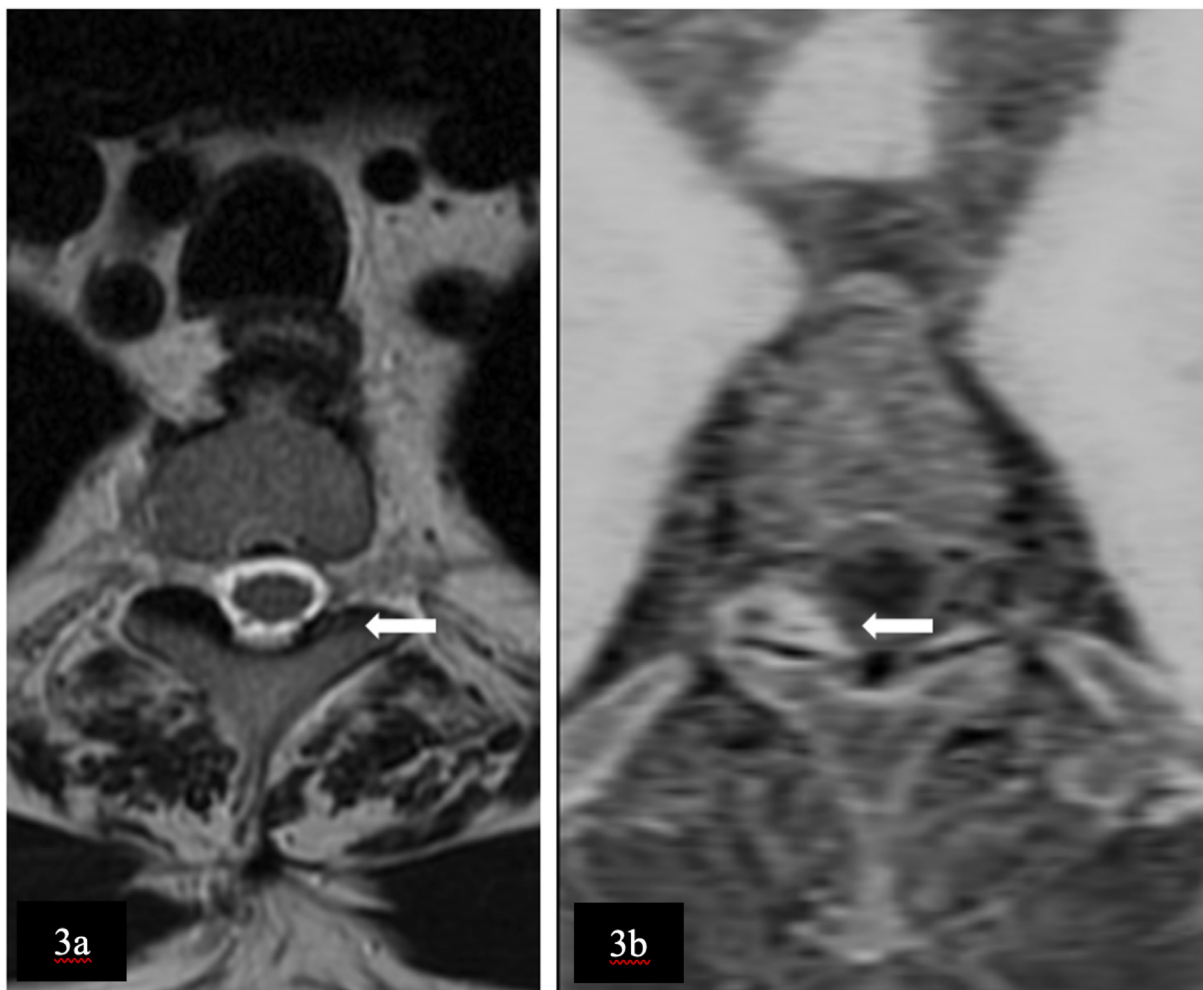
53-year-old female with degenerative disc disease of the lumbar spine and lumbar canal stenosis. (A) Axial T2-weighted MRI with poorly visualized ligamentum flavum ossification. (B) Axial BTFE reformat at the same level showing bilateral ligamentum flavum ossification.
